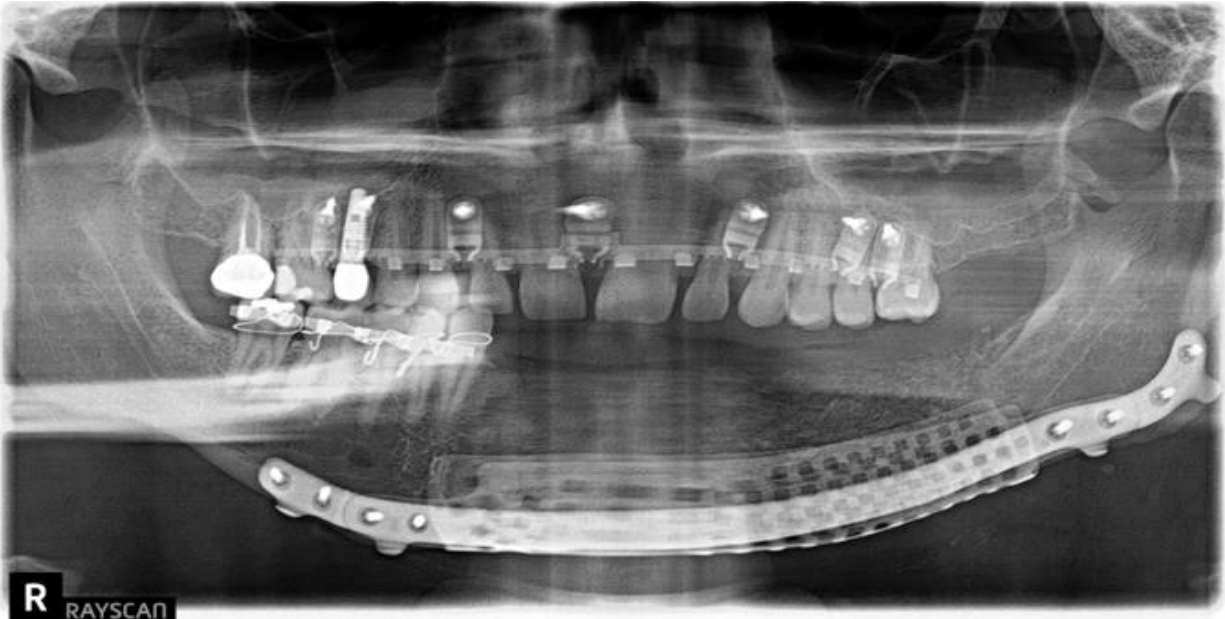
Post-operative panoramic radiograph following initial AICBG.
